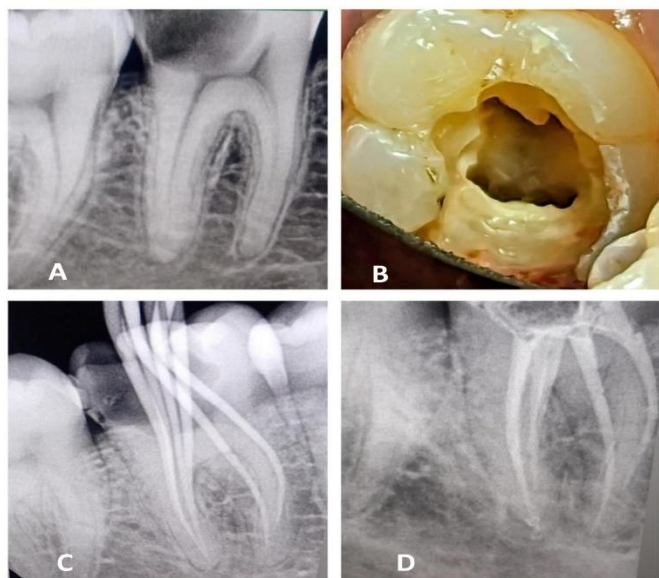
Endodontic management of Mandibular First Molar; 1A: Pre-Operative radiograph; 1B: Access opening showing 4 distal canals and 2 mesial canals; 1C: Mastercone radiograph; 1D: Obturation radiograph
